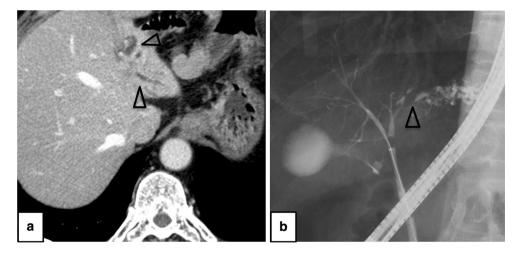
Findings of computed tomography and endoscopic retrograde cholangiography (ERC). a Computed tomography revealed limited dilation of the intrahepatic bile duct in the lateral segment of the liver (*arrowheads*), although no tumor was detected. b ERC demonstrated
